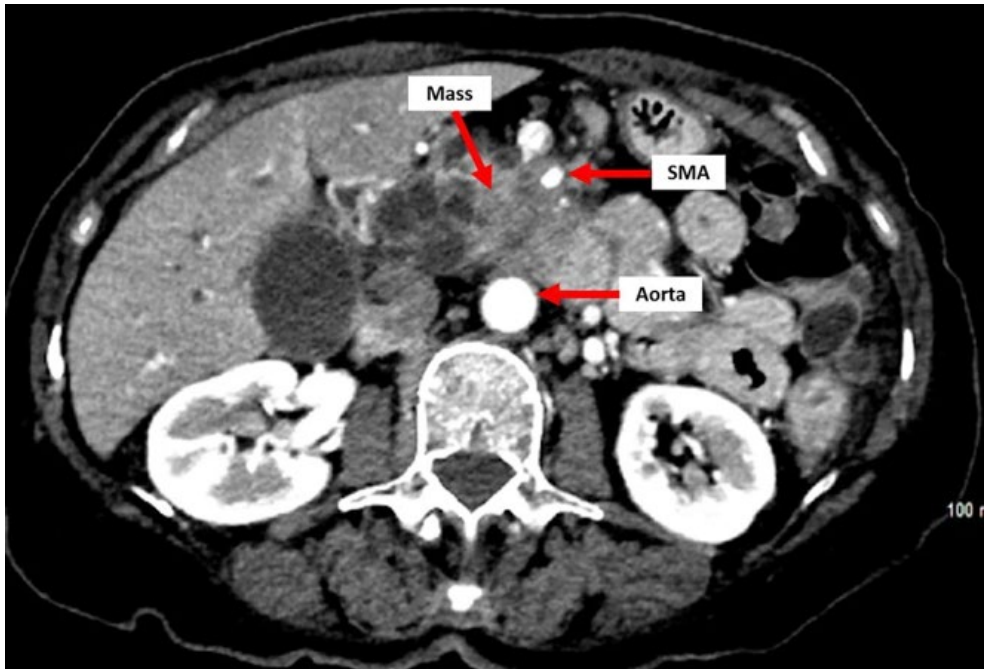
Portovenous phase axial CT of a locally advanced pancreatic ductal adenocarcinoma of the pancreatic body. Reproduced with permission from the article by Kulkarni et al. [52].
